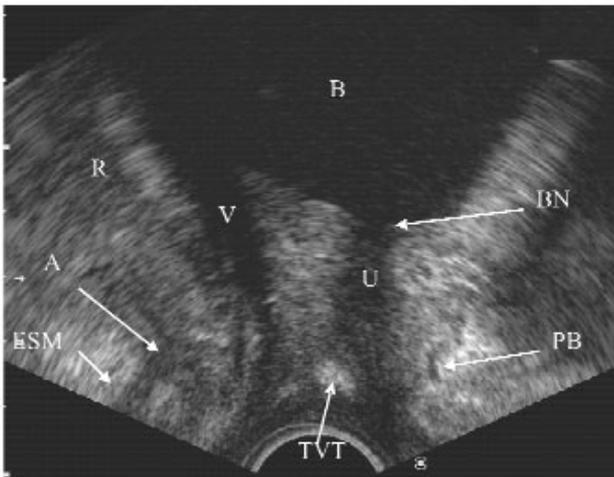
Perineal ultrasound demonstrating the bladder (B), the bladder neck (BN), the urethra (U), the pubic bone (PB), the vagina (V), the rectum (R), the external sphincter (ESM), and the anus (A) after successful vaginal tape surgery.
